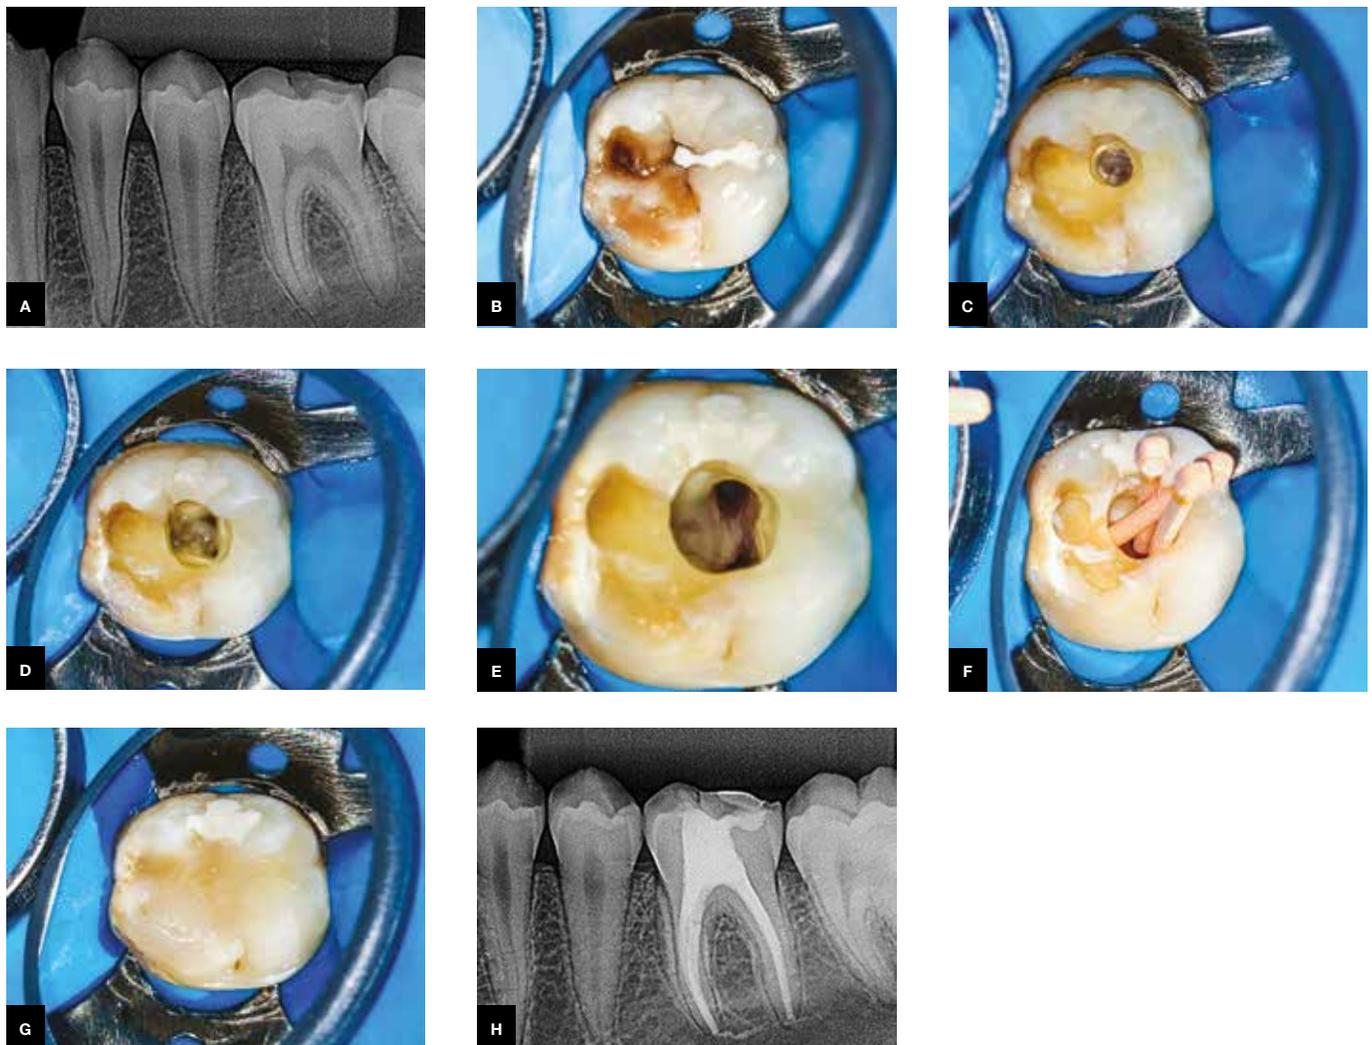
A) Initial radiograph indicating the presence of a periradicular lesion at the mesial root of tooth # 46. B) Occlusal surface showing the presence of caries. C) Endodontic access cavity initiated. D) Image after access cavity was completed. E) Post-instrumentation image of the root canals. F) Selection of gutta-percha cones. G) Restoration with flow resin (Tetric N-Ceram Ivoclar Vivadent). H) Final radiograph after endodontic treatment.
